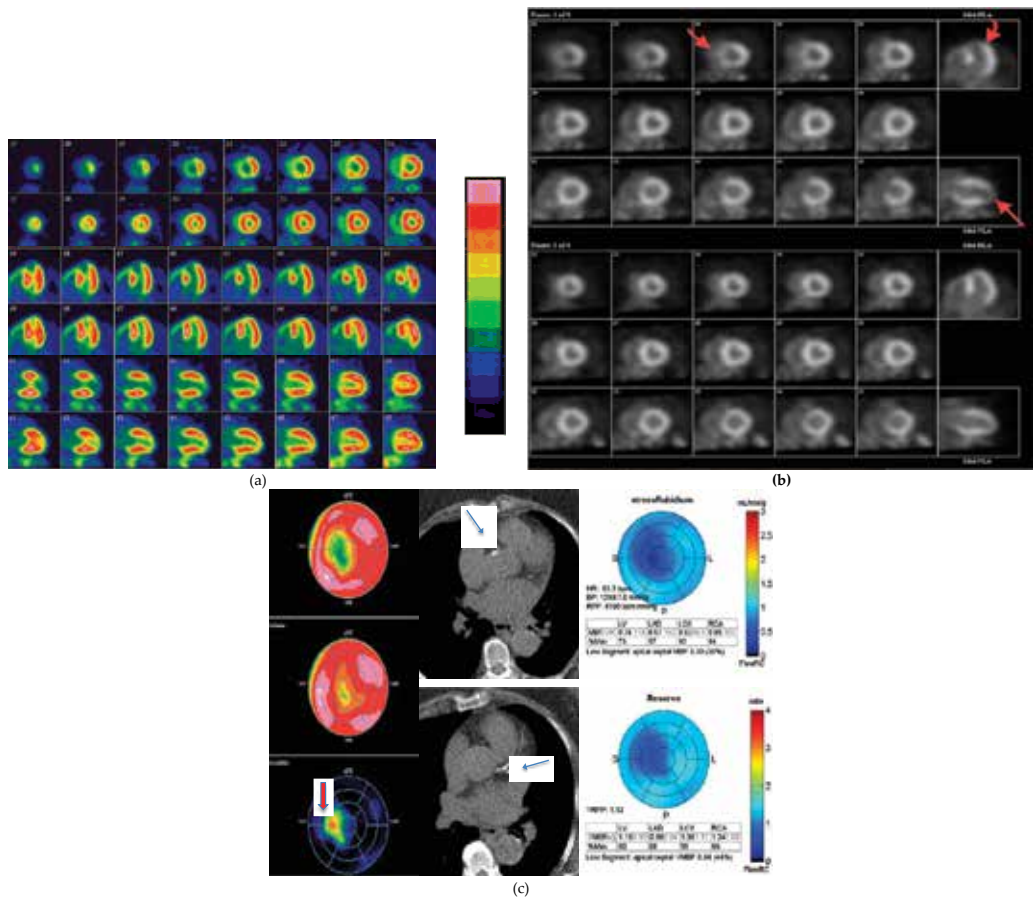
(a) Following stress, there is mild to moderate reduction in tracer uptake in the apical (distal) segments of the septum and anterior wall, and apex, which predominantly improves at the rest. This is consistent with a moderate sized area of moderate ischemia in the distal LAD territory. Stress images (rows 1, 3, and 5) and rest images (rows 2, 4, and 6). (b) Gated stress (top 3 rows) and gated rest (bottom 3 rows) during PET MPI. Normal LVEF and wall motion at rest. Following stress, there is mild hypokinesia in the apical (distal) septum and apex consistent with stress induced ischemia (red arrows). Stress acquisition during PET MPI is acquired at peak stress, and hence presence of regional wall motion is specific for ischemia. This differs from post-stress acquisition during SPECT which is delayed by 30 to 45 minutes. (c) Polar map shows the extent of reversible ischemia in the LAD territory (red arrow). CT shows presence of coronary calcification in the RCA (top, blue arrow), LCX and LAD (bottom, blue arrow). MBF demonstrate marked reduction in stress flow in the areas of reduced perfusion (global MBF= 0.74 ml/min/g), as depicted by the polar map which is labelled as stress Rubidium. Global MFR is reduced at 1.16, and 0.99 (after correction for RPP). There is reduced regional MFR in all three coronary artery territories (LAD= 0.98, LCX= 1.38, and RCA= 1.24), as seen on the polar map labelled as Reserve. The MFR finding is suggestive of underlying triple vessel disease. Measurement of MBF is corrected for rate-pressure product (RPP), and depicted in the shade of gray, next to the uncorrected values.
